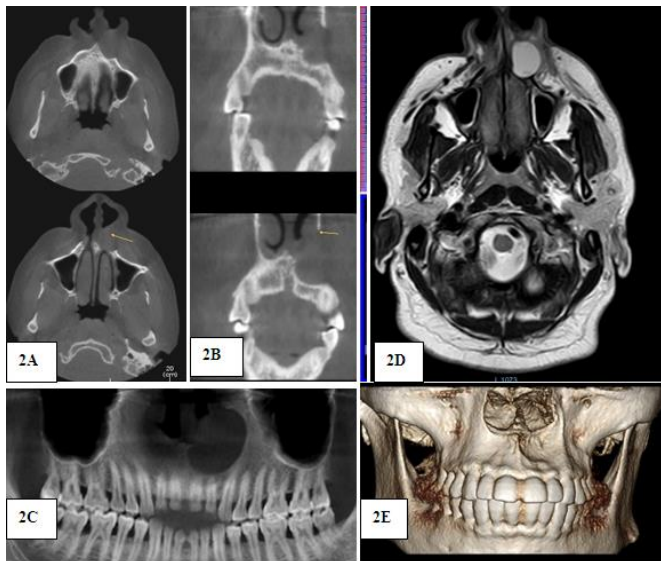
2A Axial cone beam computed tomography (CBCT) showing hypodense lesion near left ala nasii.,2B Coronal CBCT showing hypodense lesion in left anterior maxillary region ,2C Panoramic section showing oval shaped hypodense lesion apical to 21,22, 2D T2 weighted axial image shows well defined hyperintense lesion on MRI ,2E: 3 Dimensional CBCT shows concavity below left side nasal floor.
